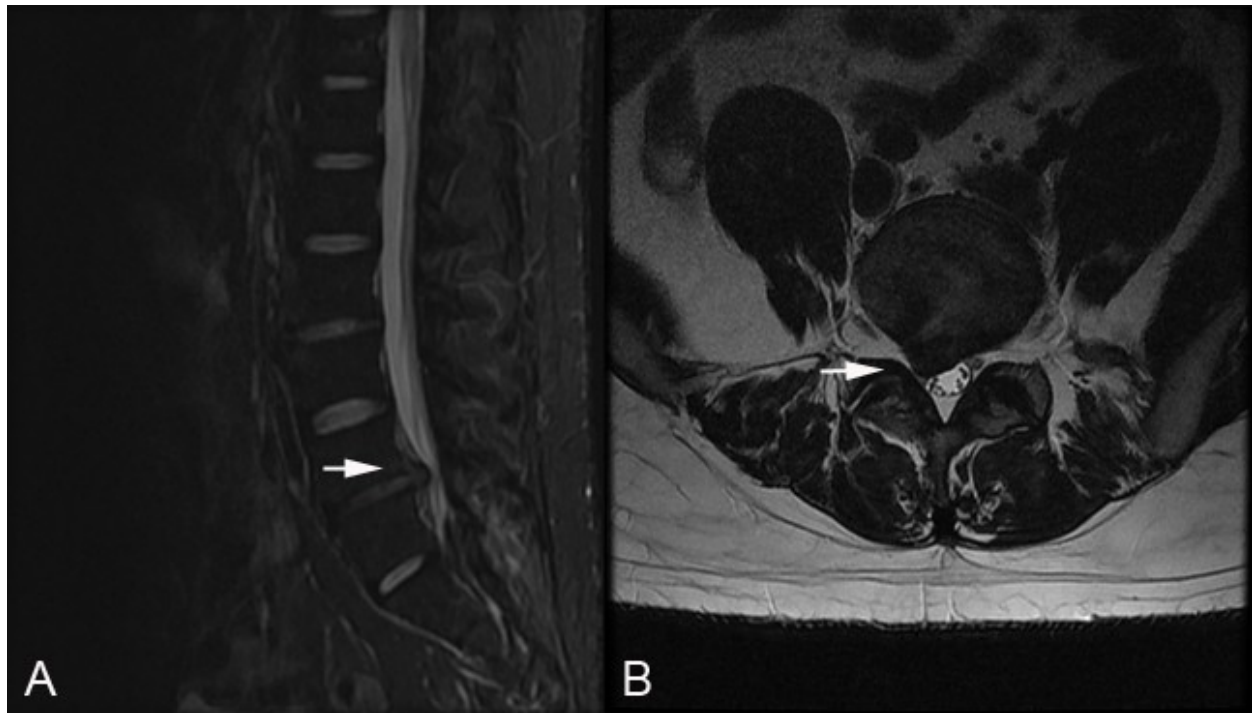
Lumbosacral MRI. a. L4-5 disc prolapse on sagittal MRI (arrow) b. L4-5 right paracentral disc extrusion compressing right L5 nerve root as it exits the thecal sac (arrow).
